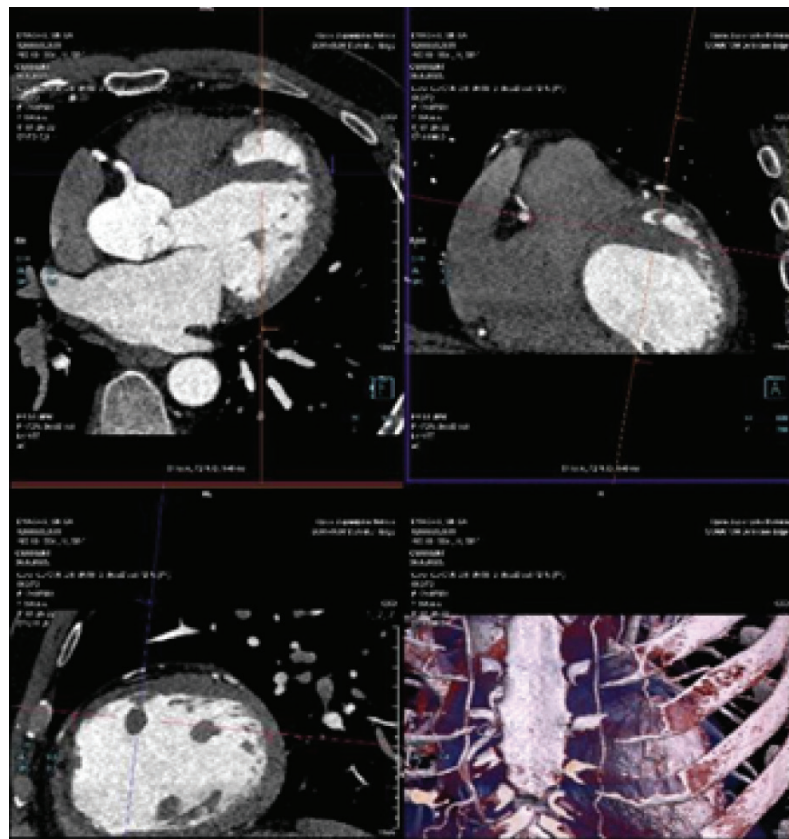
Left ventricular tumor on cardiac computed tomography.
